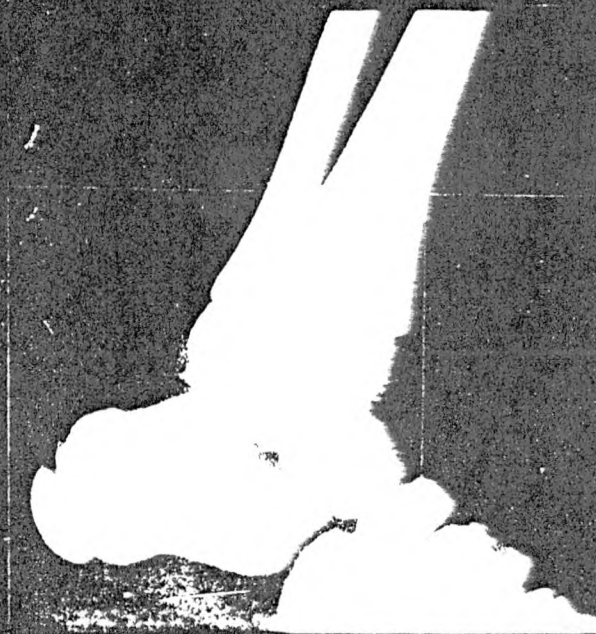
(case 3).—X-ray photograph of the ankle of F. S., aged 7½, showing a shadow 1 cm. broad marking the lower ends of the tibia and fibula. The shadow is obviously formed by a summation of the shadows of the trabeculae which are thought to be more numerous and perhaps larger in the affected than in the adjacent normal parts. The width of the shadow in a child, aged 7, indicates that the factor responsible for the shadow, lead, has been in operation a long time.
